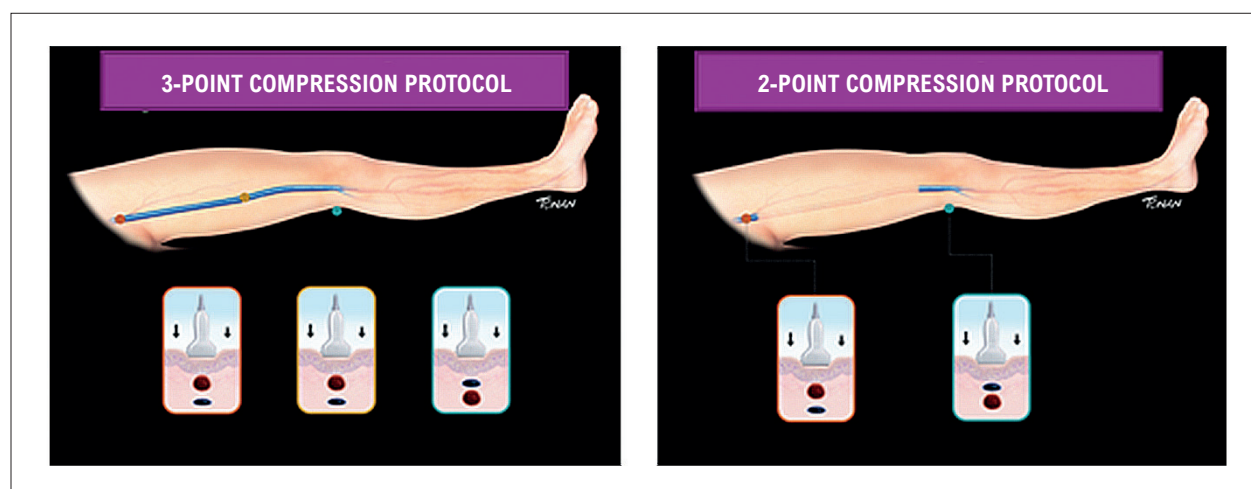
Extended compression ultrasound (CUS) protocol (3-point; A); CUS protocol (2-point; B).
